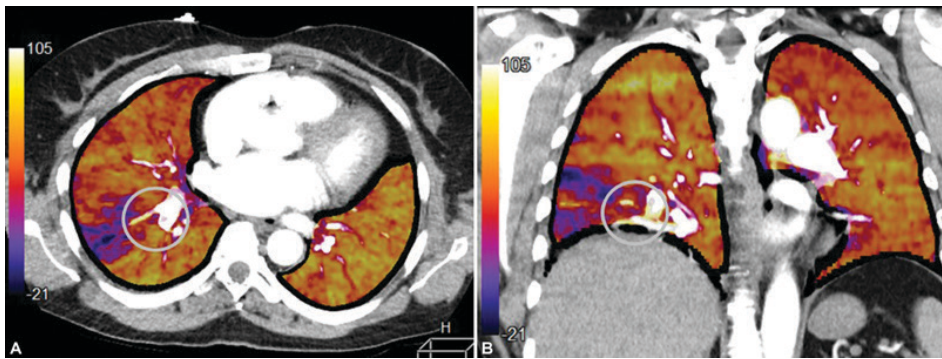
Computed tomography pulmonary angiography (CTPA) images.
